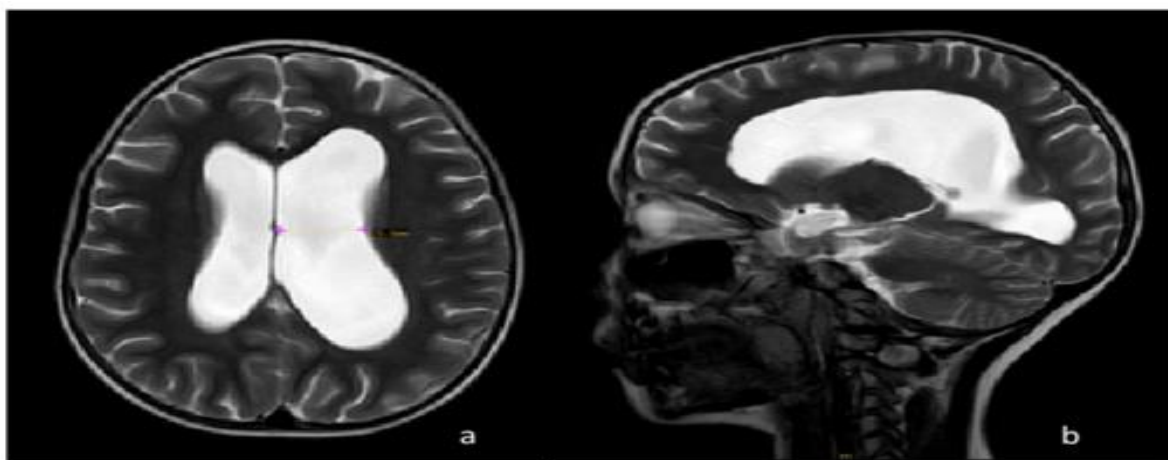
Brain MRI showing dilated ventricles, especially the left lateral ventricle
